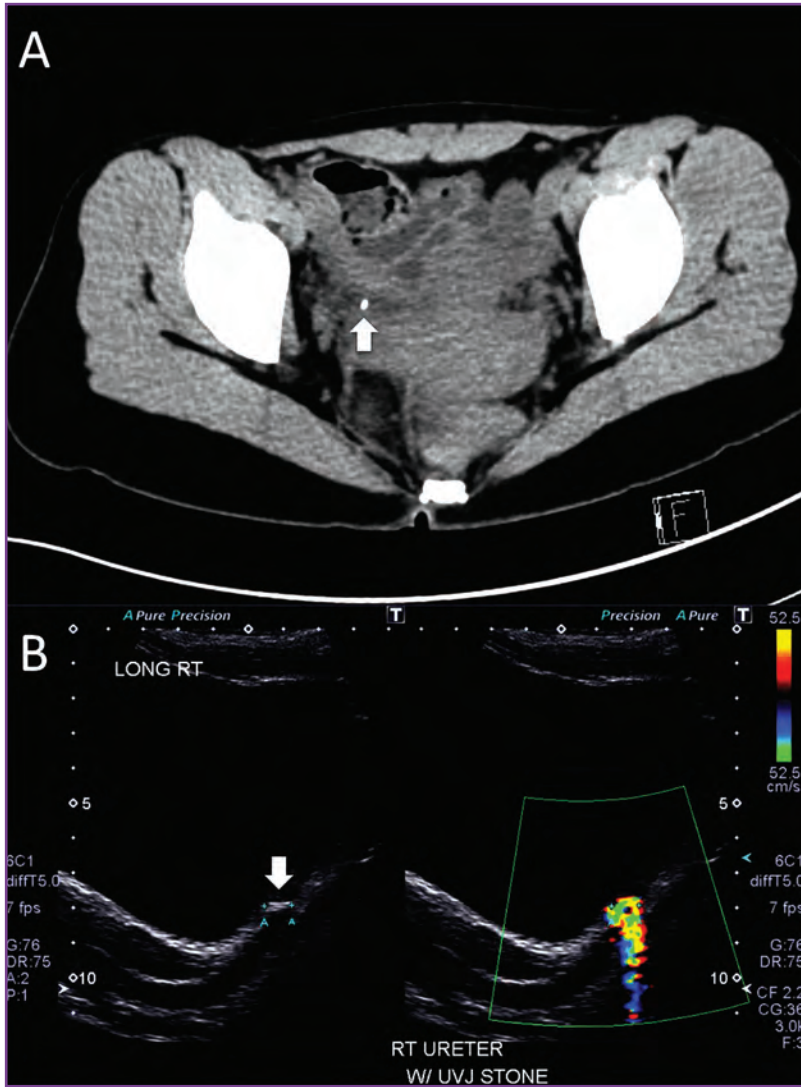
Computed tomography (CT) and ultrasonography (US) in a 16-year-old female patient with right renal colic. A, Nonenhanced axial CT of the abdomen and pelvis was initially performed at a local hospital and demonstrated a 5-mm stone in the right distal ureter (arrow) with mild right hydroureteronephrosis. B, Doppler renal and bladder US was performed for worsening symptoms about 1 week later and demonstrated the stone at the right ureterovesical junction (arrow), with twinkling artifact on Doppler images and slightly increased right hydroureteronephrosis. The patient ultimately underwent right ureteroscopy with laser lithotripsy and stone basket extraction because of a failure of medical expulsive therapy.
